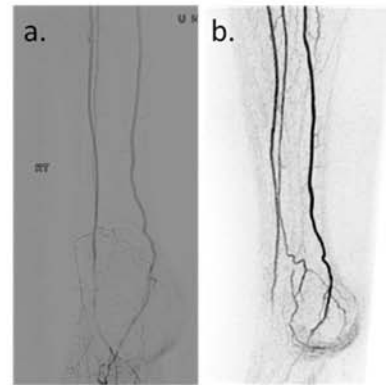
a) X-Ray DSA image of distal calf and foot arteries of a patient with PVD. b) Reformatted IVD-HYCR MRA of the same patient.
